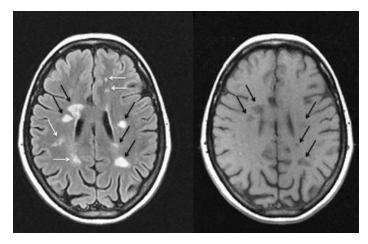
Brain Lesion in an MRI patient on an MRI scan. White and black arrows point at brain lesions.
